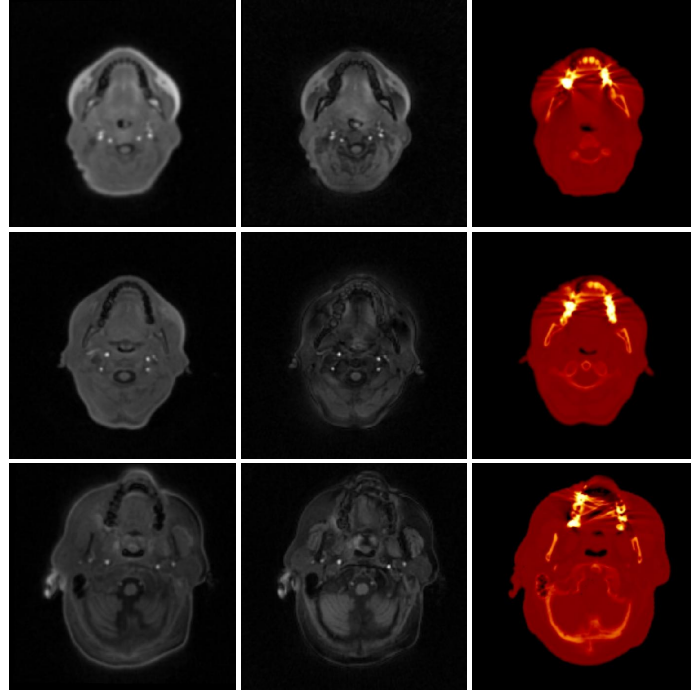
Metal artefacts for 3 different subjects. At left: UTE1 images; at the center: UTE2 images; and at right: CT images. Streak artefacts can be seen in the CT images.
